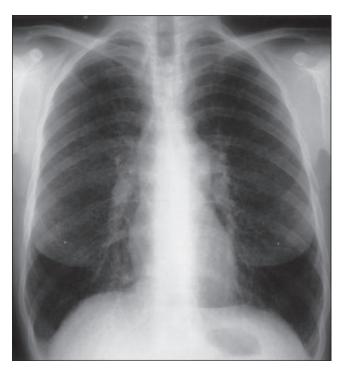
LCH. Posteroanterior chest radiograph demonstrating finely nodular densities throughout the lung parenchyma and hyperinflation in a 38-year-old woman with pulmonary LCH.
